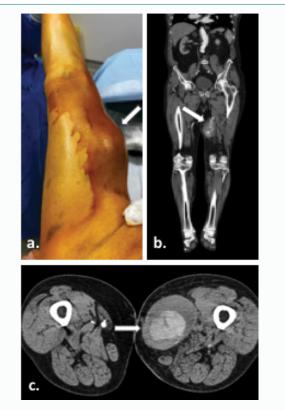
Clinical and CT-scan preoperative aspects of this bulky, native SFA-Aneurysm: A) the initial clinical presentation noted at the "Emergency Room". It appears evident (arrow) a huge and painful pulsatile mass on the medial aspect of the left thigh. B) Same aspect depicted by the Angio-CT performed in the same setting. The presence of a bulky aneurismal mass (white arrow) along the left SFA course is described. C) More detailed CT view allowed by an axial incidence, showing the intimate topography of this giant SFA aneurism, however exempt from leakage, or peri-adventitial hematoma at that stage.
